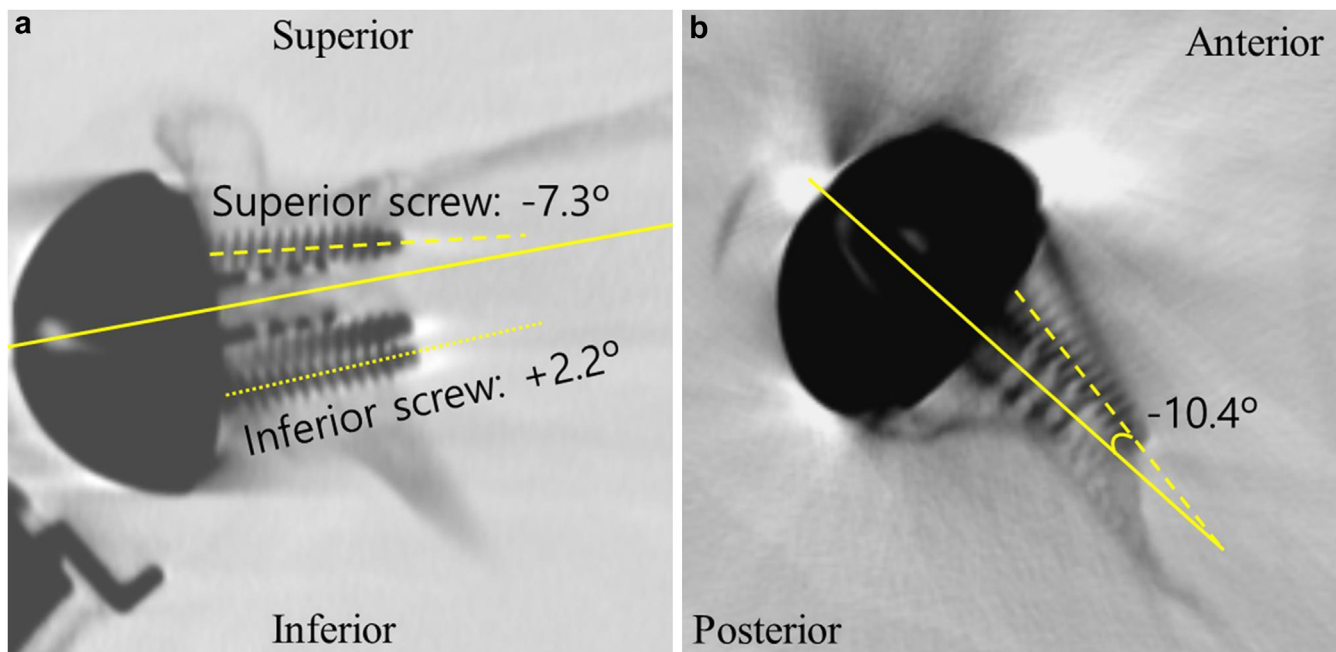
Measurement of screw orientation in 2-month postoperative CT. (a) The superoinferior orientation of screws (–), based on the central cage axis (–), was measured in the oblique coronal view. Note that positive values indicate a superior direction, while negative values indicate an inferior direction compared to the central cage axis. (b) The anteroposterior orientation of screw (–), based on the central cage line (–), was measured in the axial view. Note that positive values indicate an anterior direction, while negative values indicate a posterior direction compared to the central cage axis. CT, computed tomography.
